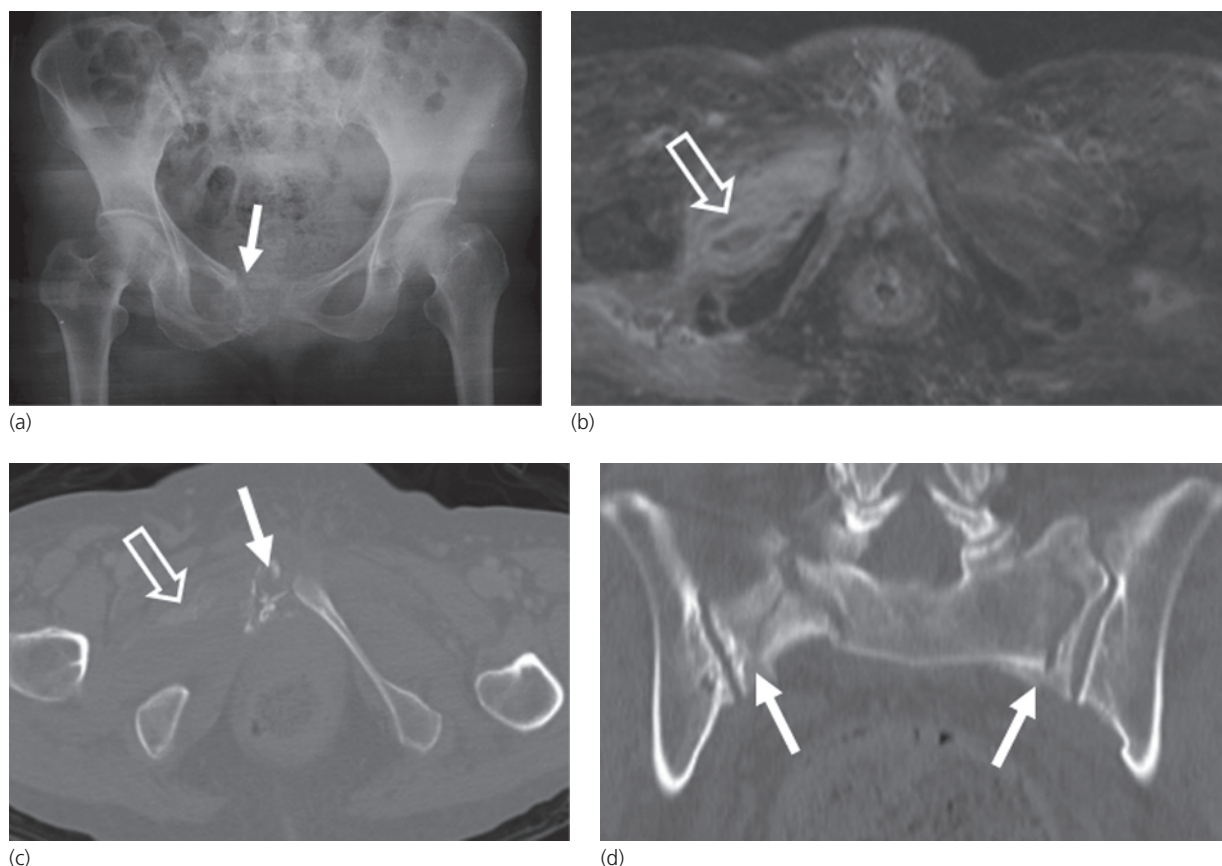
Pelvic insufficiency fractures. (a) AP radiograph shows a right pubic body and adjacent pubic rami healing fractures (arrow) evident by patchy sclerosis and lucency. (b) Axial T2-weighted, fat-suppressed image shows soft tissue edema and central low signal areas (open arrow) in the region of right adductor musculature. (c) Axial CT image shows the right pubic body fracture (closed arrow) and heterotopic ossification (open arrow) in the adductor musculature corresponding to the low signal region on MR in (b). (d) Coronal reformatted CT image shows associated sacral ala fractures bilaterally (arrows).
